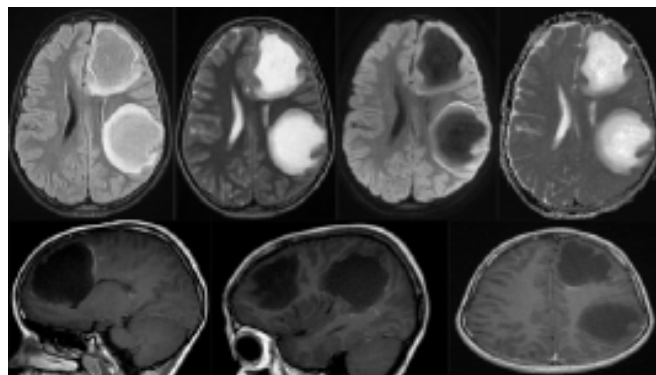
A 9-year-old boy presented with headache, ataxia, and dysarthria for 2 months. Two large intra-axial, mildly expansile mass-like abnormalities centered within the left cerebral hemisphere white matter regions, with relative preservation of the overlying cortex. Imaging: T2WI hyperintensity with partial central FLAIR suppression, faint incomplete marginal enhancement, and marginal curvilinear areas of mild diffusion restriction causing mild rightward midline shift, mild effacement of left lateral ventricle, and left hemispheric sulcal effacement. The degree of mass effect is disproportionate to the lesion's size. No optic nerves or spinal cord lesions. The conclusive diagnosis is tumefactive demyelination lesions.
